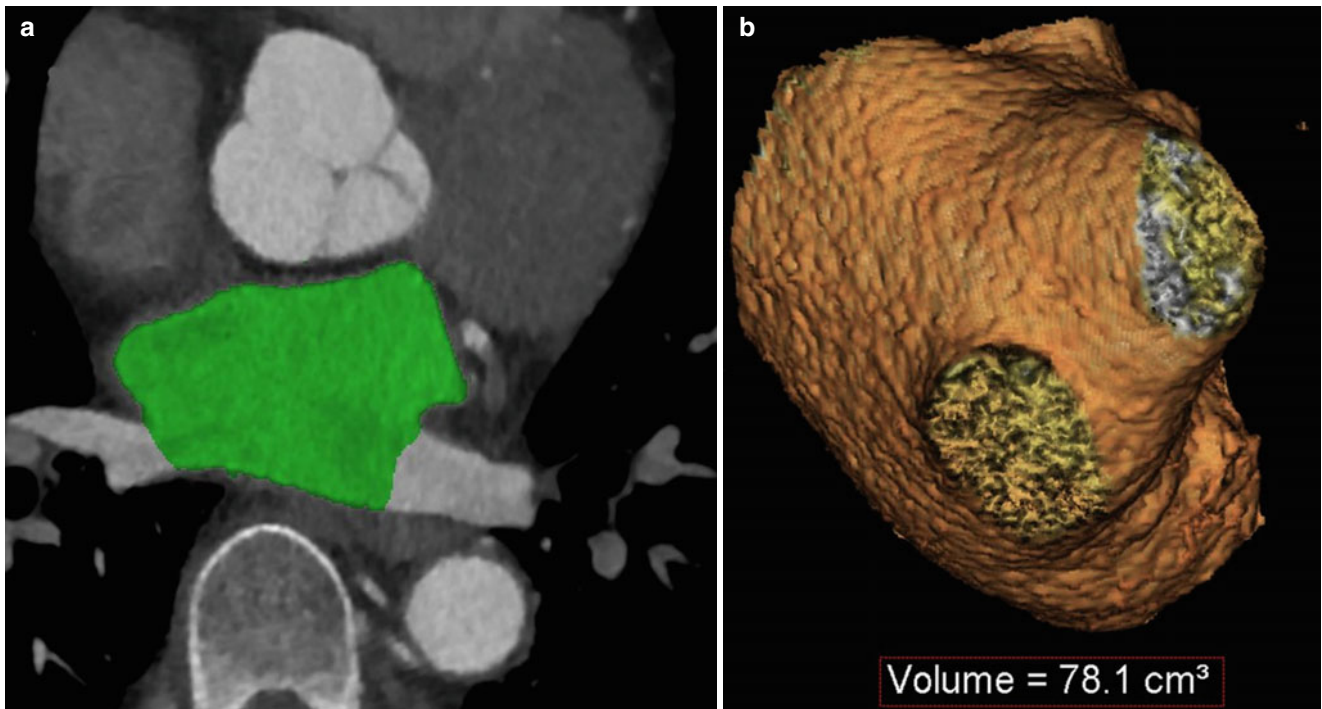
Quantification of the left atrium by using cardiac CT. Transverse cardiac CT image (a) shows a segmentation of the left atrium (green), and 3D volume-rendered CT image (b) provided a quantification of left atrial volume, 78.1 cm³
